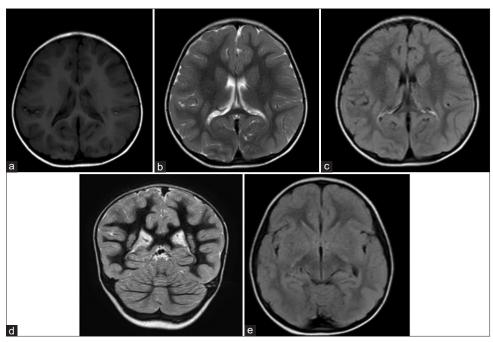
Migrational disorder. There is gray matter like signal intensity area in bilateral parietal periventricular region appearing hypointense on axial T1W (a), isointense on axial T2W (b), FLAIR (c), and coronal T1W-IR images s/o heterotopia (band like). Paucity of sulcations in bilateral cerebral hemispheres.
